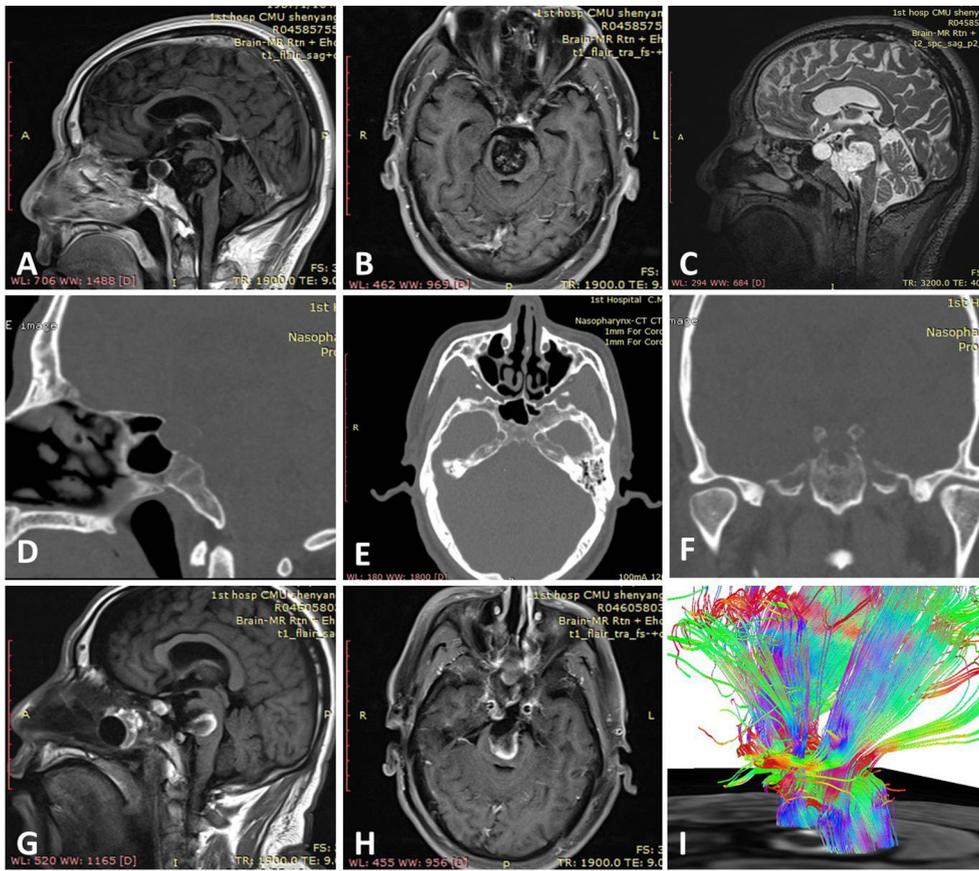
A–C: Preoperative sagittal (A and C) and axial (B) MR images demonstrating a 2.4 × 2.7-cm ventromedial pontine lesion. D–F: Preoperative sagittal (A), axial (B), and coronal (C) CT images demonstrating rugged bony defect of the dorsal clivus and the dorsum sellae. G–H: Postoperative sagittal (A) and axial (B) MR images demonstrating a near-total tumor resection via endoscopic endonasal transclival approach. I: Postoperative DTI demonstrating preservation of the CSTs that were displaced posteriorly by the lesion.
